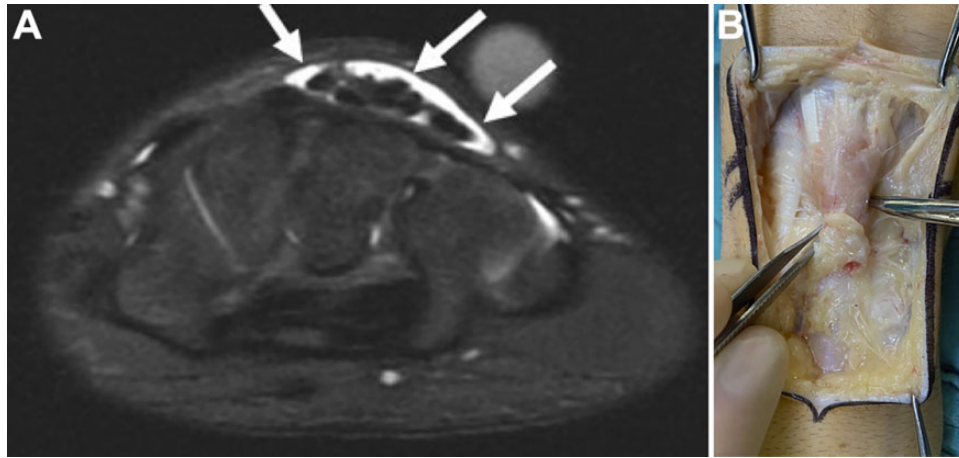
(A) Fat-suppressed T2-weighted magnetic resonance imaging scan obtained in a 17-year-old gymnast with inflammation within the fourth extensor compartment (arrows) indicative of tenosynovitis caused by overuse and dorsal impingement by an underlying carpal boss found on other imaging studies. (B) Intraoperative photograph obtained in a patient with extensor digitorum communis tenosynovitis; note the thickened tenosynovium adjacent to the distal border of the extensor retinaculum (shown between the surgical instruments) causing dorsal wrist impingement, pain, and disability in this patient. (Image A reproduced with permission by Fritz RC, Boutin RD. *Musculotendinous disorders in the upper extremity, part 2: MRI of the elbow, forearm, wrist, and hand. Semin Musculoskelet Radiol.* 2017;21[4]:376-391.)
